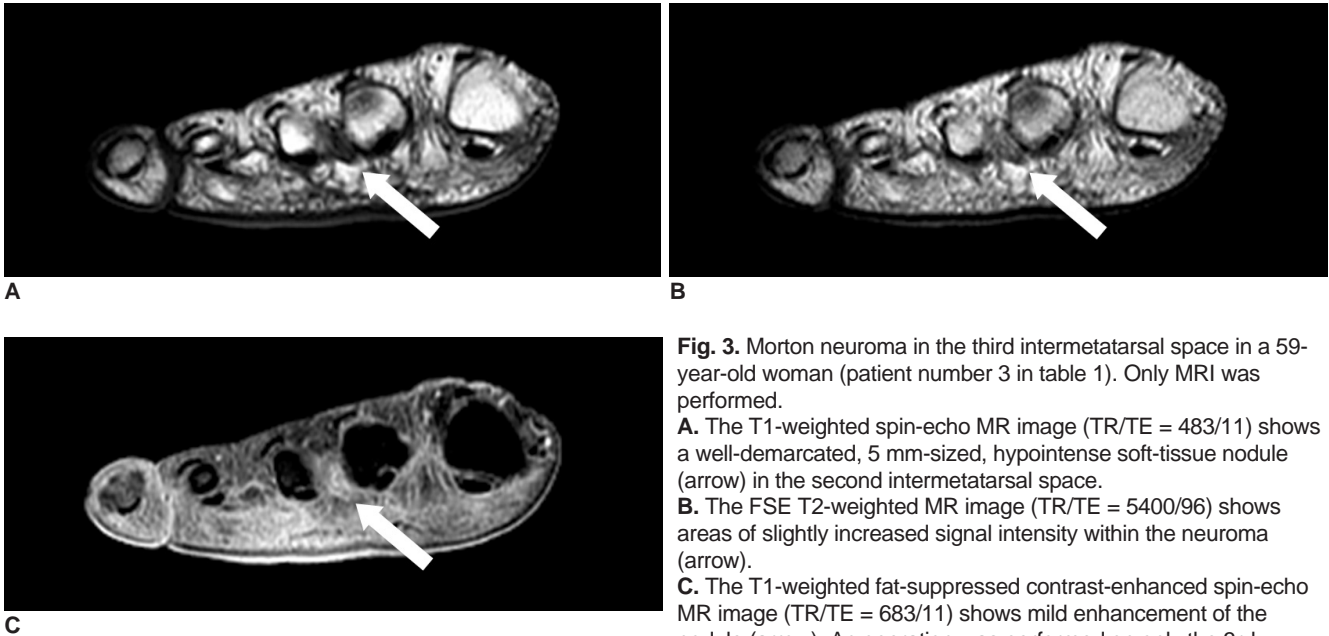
Morton neuroma in the third intermetatarsal space in a 59-year-old woman (patient number 3 in table 1). Only MRI was performed.
